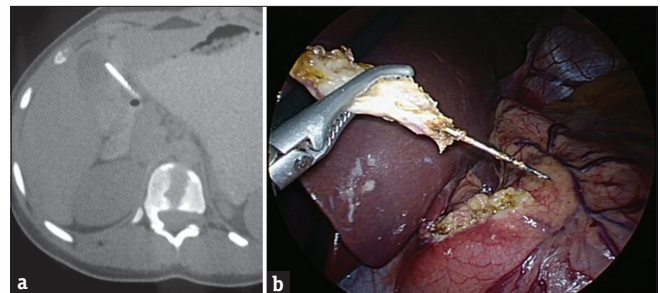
(a) Computed tomography scan showing foreign body (pin) in gastrohepatic ligament. (b) Pin being extracted from the gastrohepatic ligament
